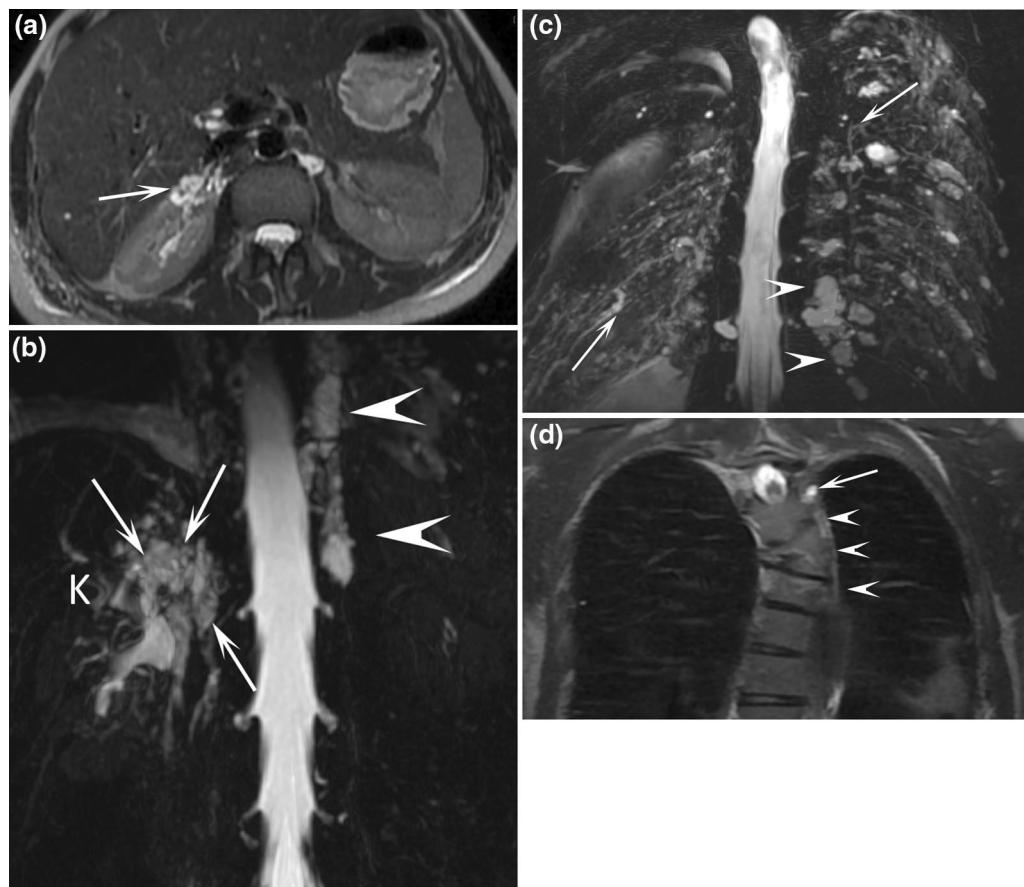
38-year-old female patient with chyluria, chylothorax, and Gorham-Stout disease. Axial T2-weighted MR image (a) demonstrated dilated and enlarged lymphatic vessels in contact with the right kidney (arrow). Coronal MR lymphography with MIP reconstruction (b) demonstrated channel type lymphatic malformation (arrows) in contact with the right kidney (K). Mixed channel and cystic lymphatic malformation (arrowheads) replaced the thoracic duct. At the thoracic level, coronal MR lymphography with MIP reconstruction c demonstrated multiple dilated intercostal lymphatic vessels (arrows) with several cystic lymphatic malformations (arrowheads). Coronal T2-weighted MR image (d) demonstrated vertebral fractures, with a hyperintense signal within three vertebrae related to progressive osteolysis caused by Gorham-Stout disease (arrowheads). A cystic lymphatic malformation in contact with the vertebra was also demonstrated (arrow)
